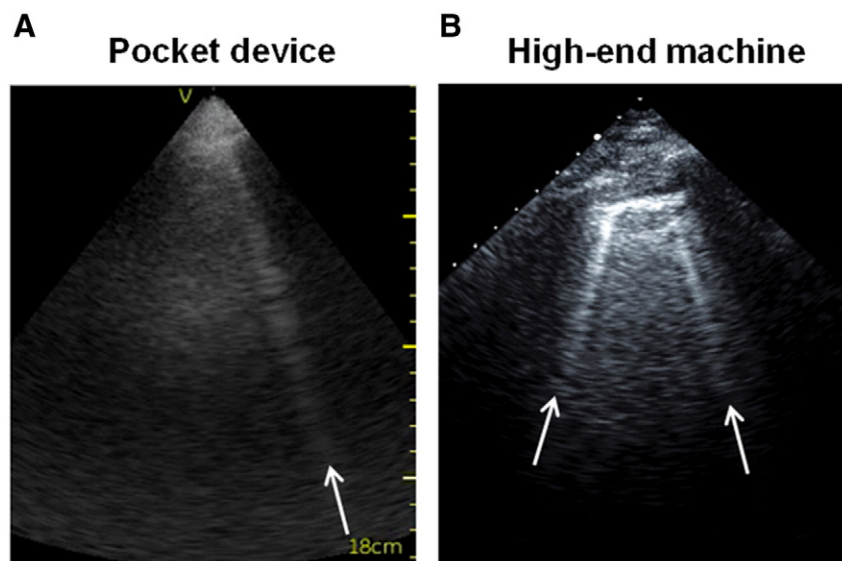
B-lines on LUS performed with a pocket device (A) and a high-end ultrasound system (B).
